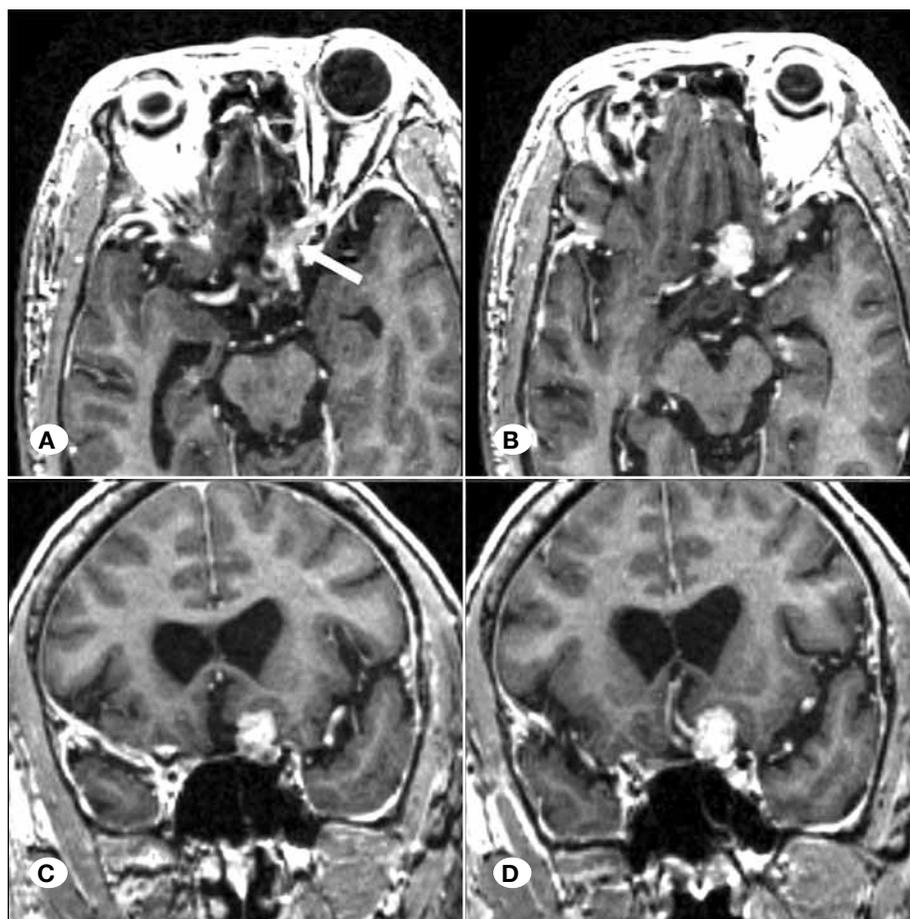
A, B) Preoperative gadolinium enhanced axial MRI of a 67-year-old man showing a well-defined 1.8 cm enhancing lesion arising from the optic nerve and extending to involve the optic canal (arrow). C, D) Gadolinium-enhanced coronal MRI showing close proximity to the branches of the anterior cerebral artery.
